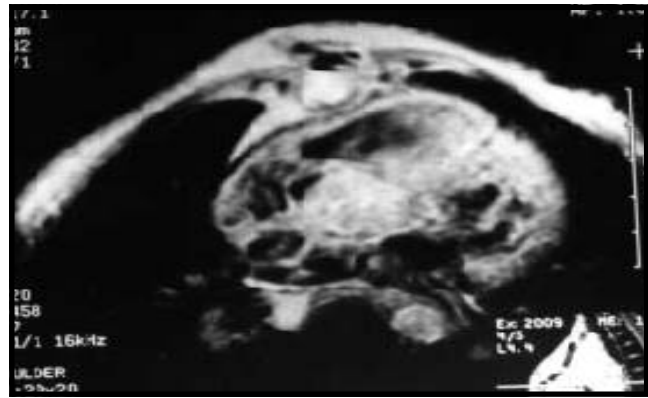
Magnetic resonance imaging (magnified view) showing pus collection around the sternal bone.
